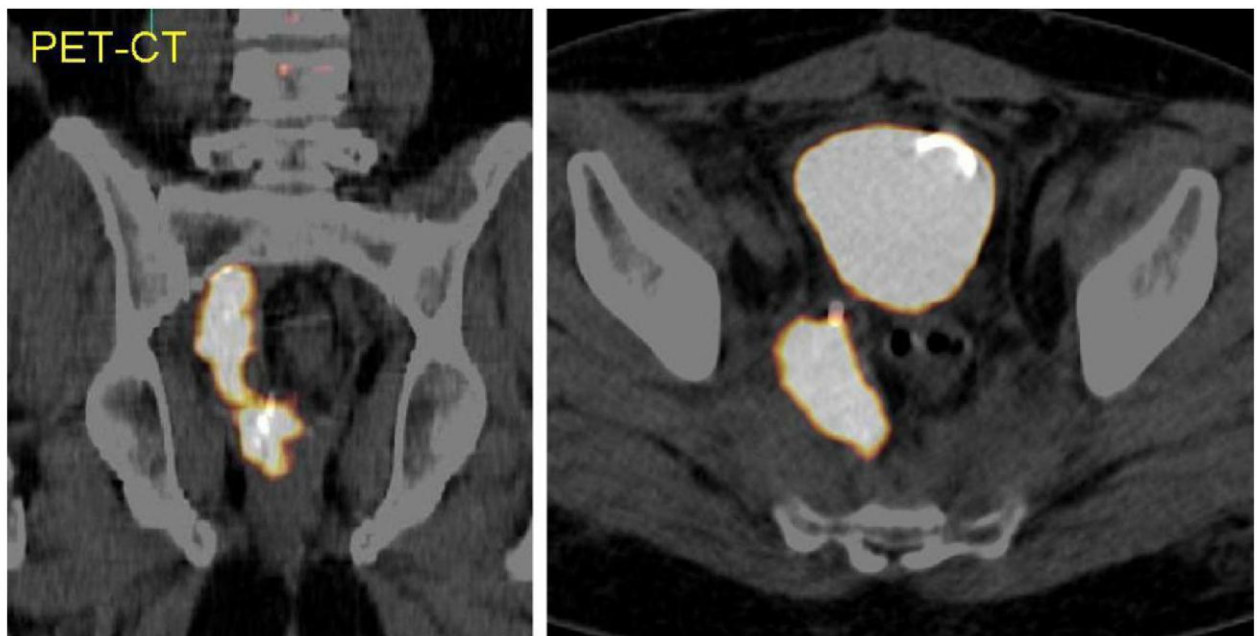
A 60-year-old patient developed rectal cancer relapse in a year period after neoadjuvant and surgery treatment of the primary rectal tumor. (pic. 5) PET-CT scans
